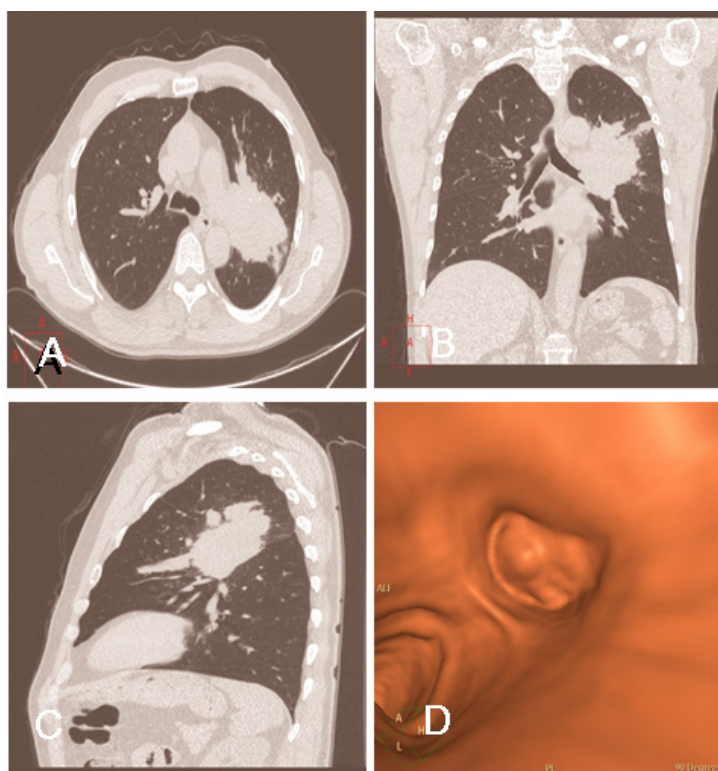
A: axial section image of chest CT at the level of the carina, lung parenchyma window. B: coronal reconstruction, lung parenchyma window. C: sagittal reconstruction, lung parenchyma window. D: endoscopic reconstruction
